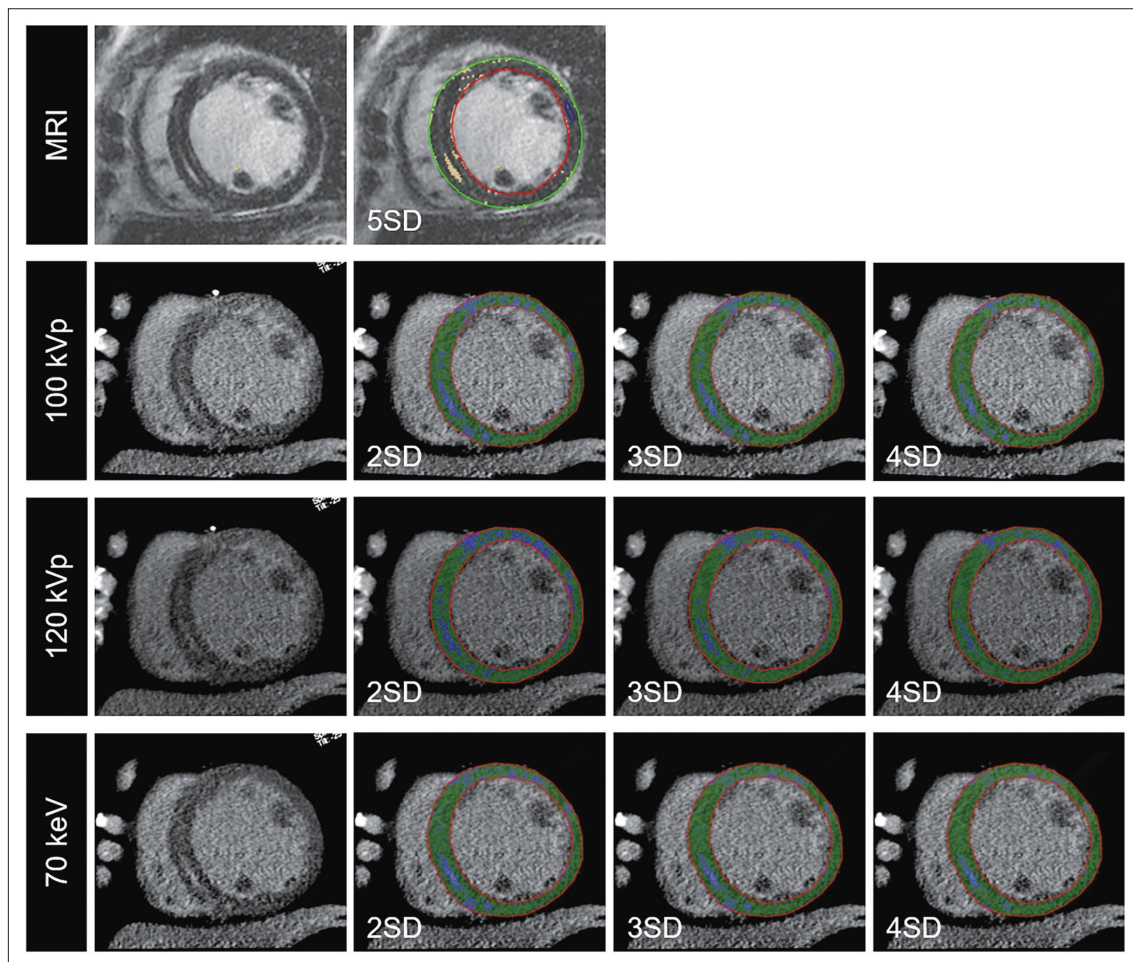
An example case of LGE and MDE quantification in a 61-year-old female with nonischemic dilated cardiomyopathy. The first row presents mid-wall LGE (yellow) in the inferior septal wall of the left ventricle, using the 5-SD threshold. In the second, third, and fourth rows, a raw image and threshold-based quantification of MDE at 100 kVp, 120 kVp, and 70 keV, respectively, are displayed. In each CT image, the blue area represents MDE, and the green area represents the non-MDE myocardium. LGE = late gadolinium enhancement, MDE = myocardial delayed enhancement, SD = standard deviation
